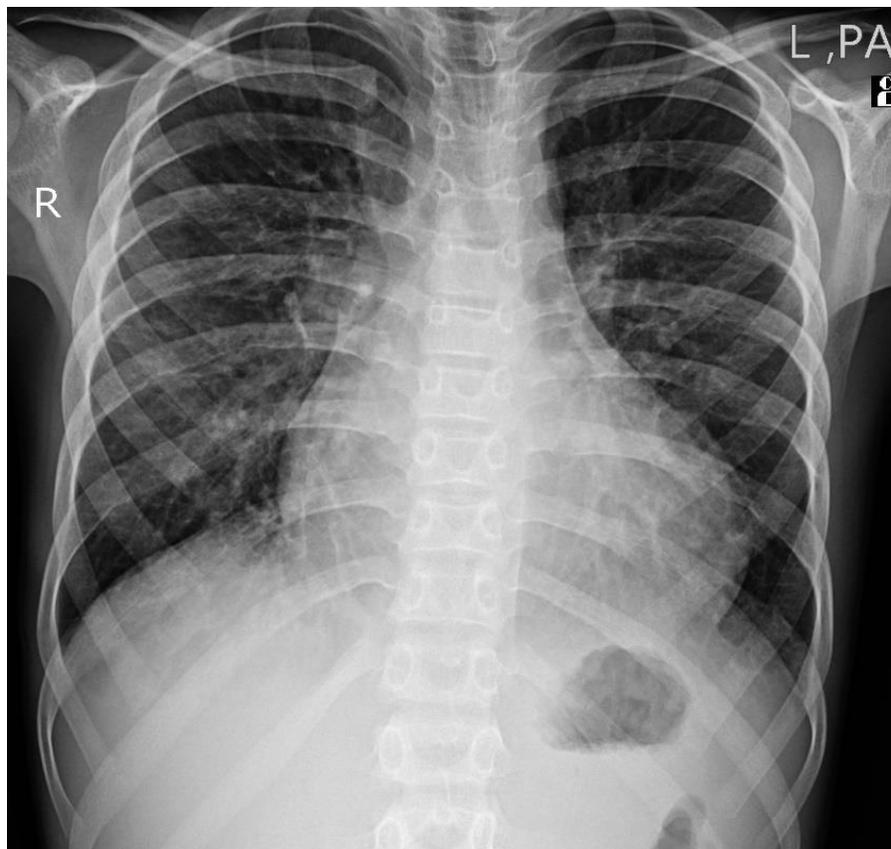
Chest radiograph showing increased pulmonary vascular markings and cardiomegaly
